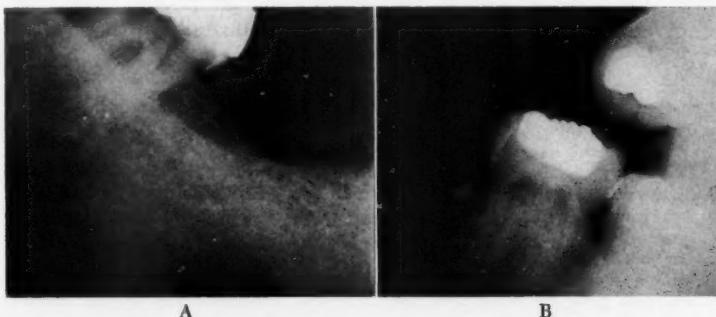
A, Periapical roentgenogram showing exostosed roots surrounded by dense bone: a preoperative indication of the possibility of dry socket. B, Post-operative roentgenogram in a patient having a dry socket following the removal of an impacted mandibular third molar. Note the piece of enamel remaining in the socket.
